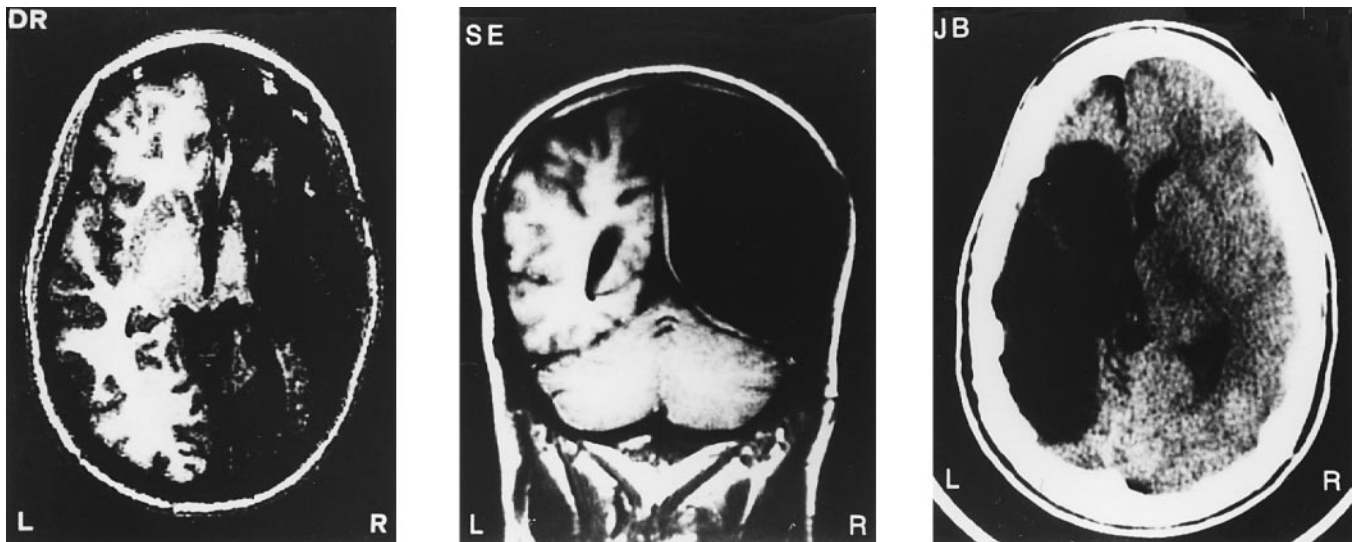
Axial and coronal MRI and axial CT images showing surgical ablation in D.R., S.E. and J.B.; see Subjects for a description of the surgical procedures.
